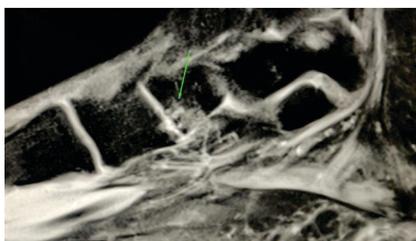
Sagittal PDW FSE MR images shows fluid signal intensity at the coalition with irregular articular surface and marrow edema in the navicular and medial cuneiform bones.
